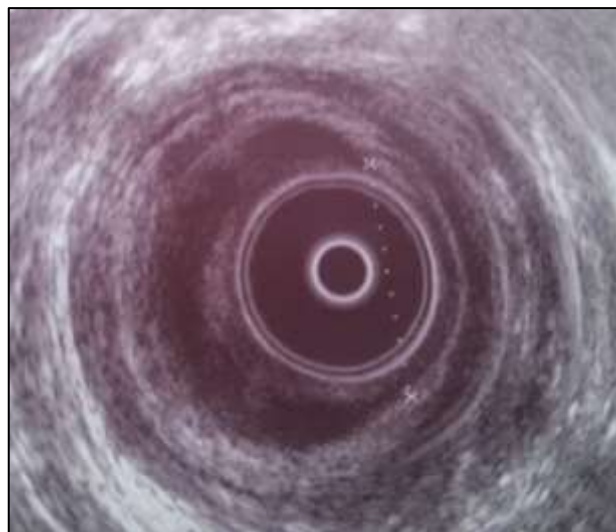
Endoanal ultrasound finding consistent with defect < 50% (group C) of the internal sphincter circumference.
